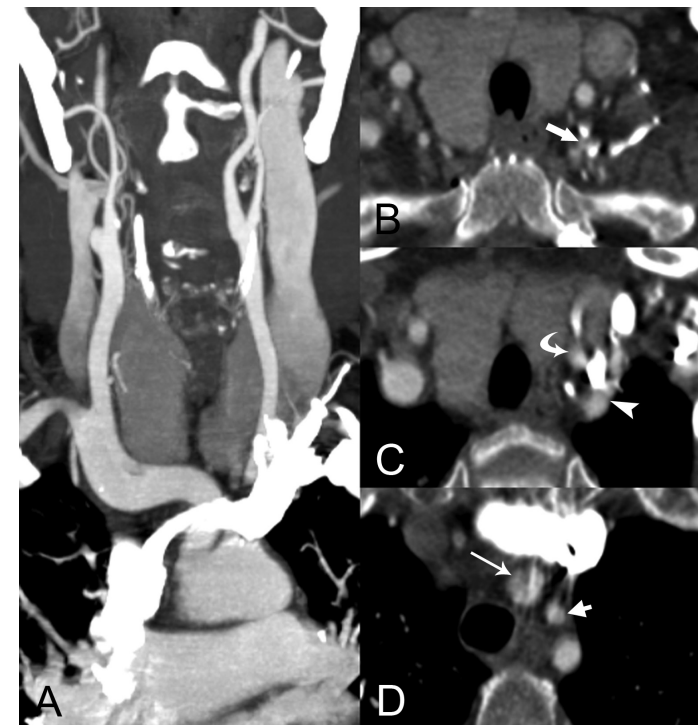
CT angiograms of supra-aortic arteries in 74-year-old woman scanned in caudocranial direction with left-sided injection of contrast material.
